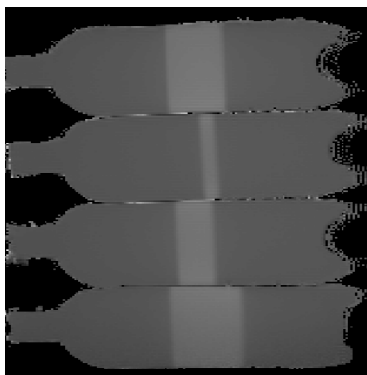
MRI of various slice widths.
